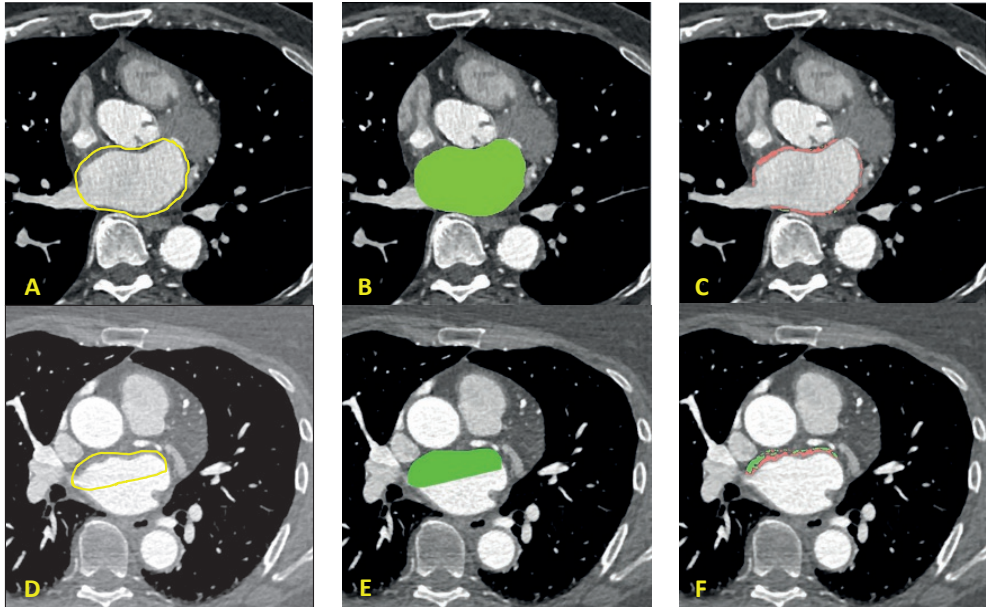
Coronary computed tomography angiography images with LA EAT and MYO measurements in the whole wall (A–C) and the roof specifically (D–F). (A and D) Manual delineation of the LA (yellow line). (B and E) Selection of the region of interest (green color). (C and F) Pixels containing MYO (red color) and EAT (green color) based on HU ranging from 10 to 120 HU and -30 to -190 HU respectively. EAT=epicardial adipose tissue; MYO=myocardial tissue; LA=left atrium; HU=Hounsfield unit.
